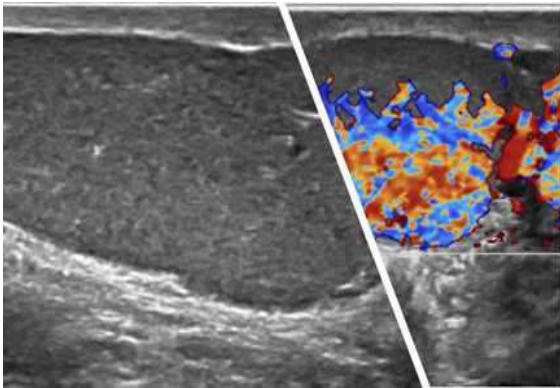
Doppler study show prominent vascularity.
